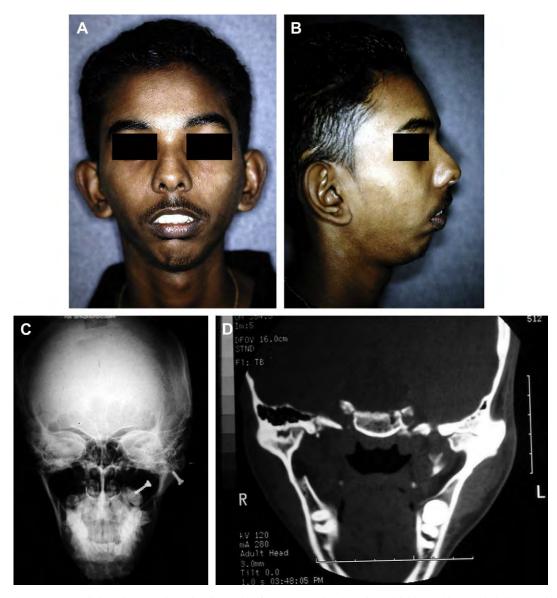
(A-D) Clinical photographs and radiographs of a 16-year-old male patient with bilateral bony ankylosis secondary to inadequately treated bilateral subcondylar fractures. Note the pronounced retrognathia due to disruption of the condylar growth center. The patient required bilateral arthroplasties, bilateral costochondral graft reconstruction, and temporalis myofascial flaps to line the newly created glenoid fossae. L, left; R, right.
